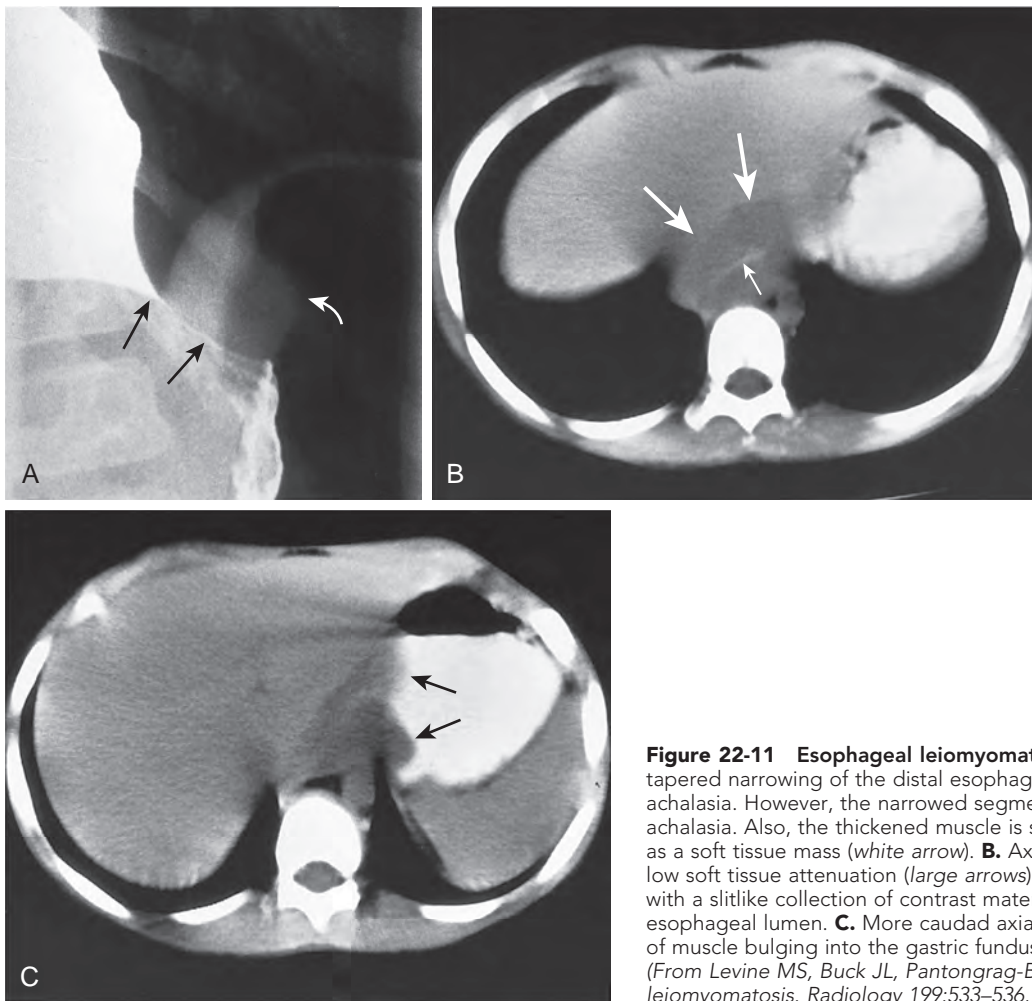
Esophageal leiomyomatosis. A. Barium study shows smooth, tapered narrowing of the distal esophagus (black arrows), resembling achalasia. However, the narrowed segment is longer than that typically seen in achalasia. Also, the thickened muscle is seen bulging into the gastric fundus as a soft tissue mass (white arrow). B. Axial CT scan shows a mass of relatively low soft tissue attenuation (large arrows) surrounding the distal esophagus with a slitlike collection of contrast material (small arrow) in the compressed esophageal lumen. C. More caudad axial CT scan shows this thickened mass of muscle bulging into the gastric fundus (arrows) on both sides of the cardia. (From Levine MS, Buck JL, Pantongrag-Brown L, et al: *Esophageal leiomyomatosis*. *Radiology* 199:533–536, 1996.)
